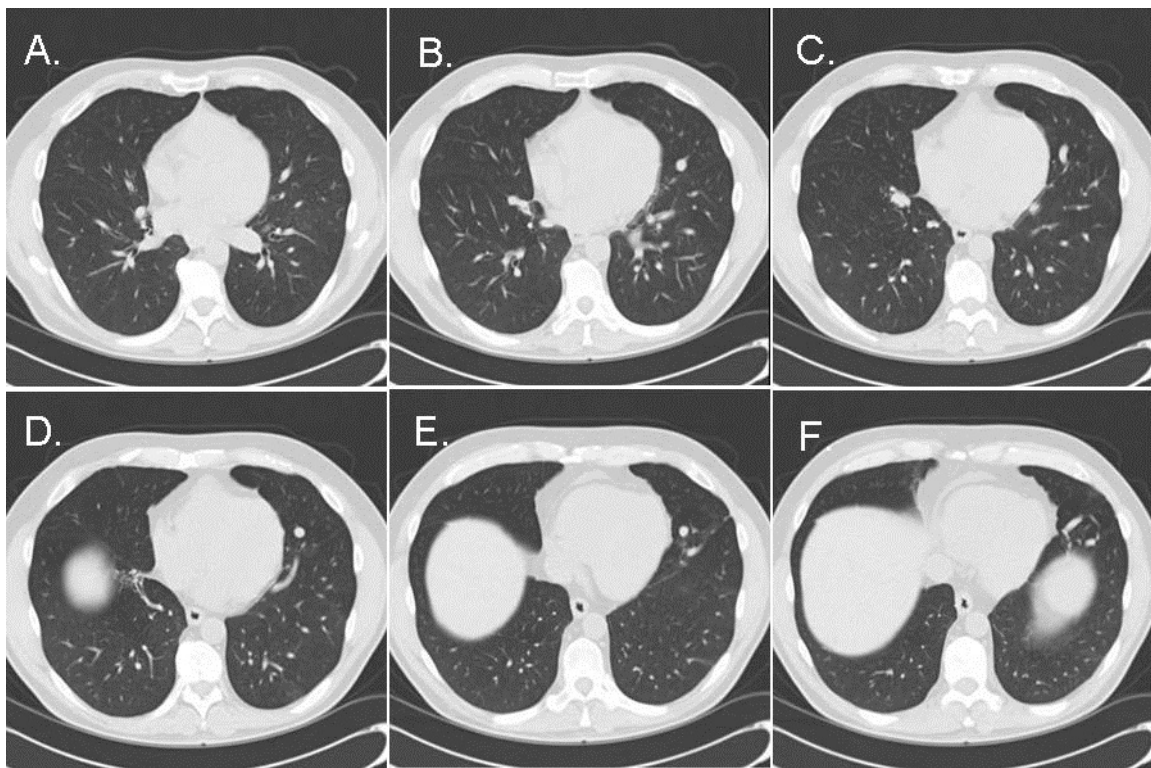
Representative images from the thoracic CT scan.
